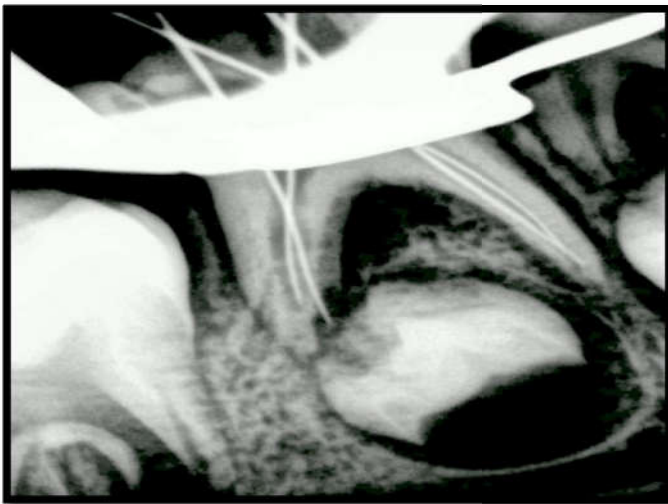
Intraoral Digital Radiograph (RVG)
